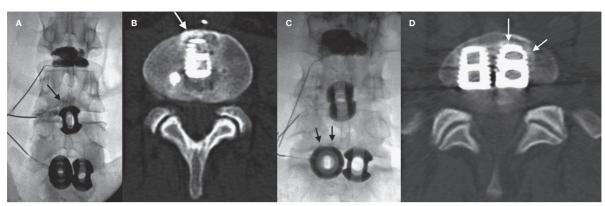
Patient is a 42-year-old man with a longstanding history of chronic low back pain with multiple prior lumbar surgeries including inter-body cage fusion at the L4-5 and L5-S1 levels. Post-fusion, he continued to have persistent low back pain. A) AP diskogram image demonstrates contrast injected into the L4-5 disk space. Contrast is seen in the residual postoperative disk space as well as surrounding the upper margin of the cage (arrow). The patient had non-concordant pain at L4-5 with no response to lidocaine injection. B) Post diskogram CT at L4-5 demonstrates contrast projecting into the peri-cage fibrous tissue (arrow). C) AP diskogram image demonstrates contrast injected into the L5-S1 disk space. A small amount of diskographic contrast is pooled around the inter-body fusion cage (arrows), but no diskographic contrast leakage was demonstrated. The patient had positive concordant pain at this level with partial improvement after lidocaine injection. D) Post diskogram CT at L5-S1 demonstrates contrast surrounding the left cage (arrows).
